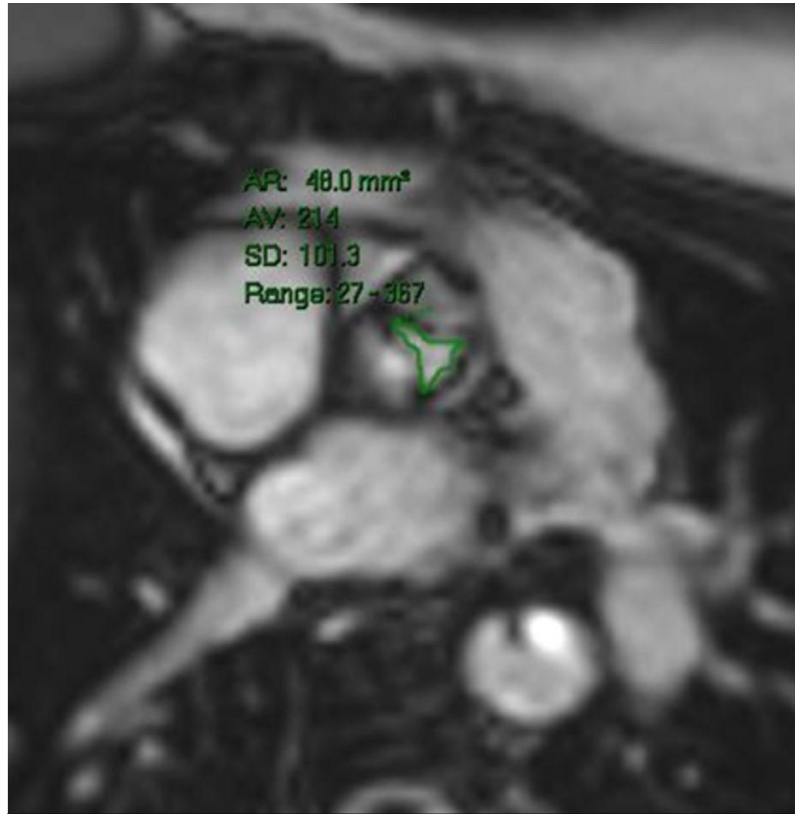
Cardiac MRI with aortic measurements demonstrated an area of 0.48 cm².
